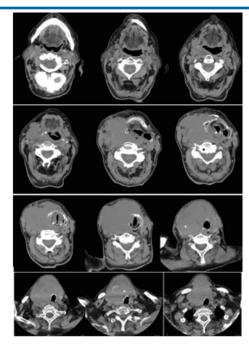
CT of the neck soft tissue/October 2021-enlarged right forehead and thyroid gland from a dense tumor with a diameter of 114 mm x 69 mm. The cervical structures are are contralateral compressed. The small section of the thyroid gland left lobe base is also infiltrated. The trachea has a preserved lumen. The smallest lumen settles in the larynx area that is edematous.
